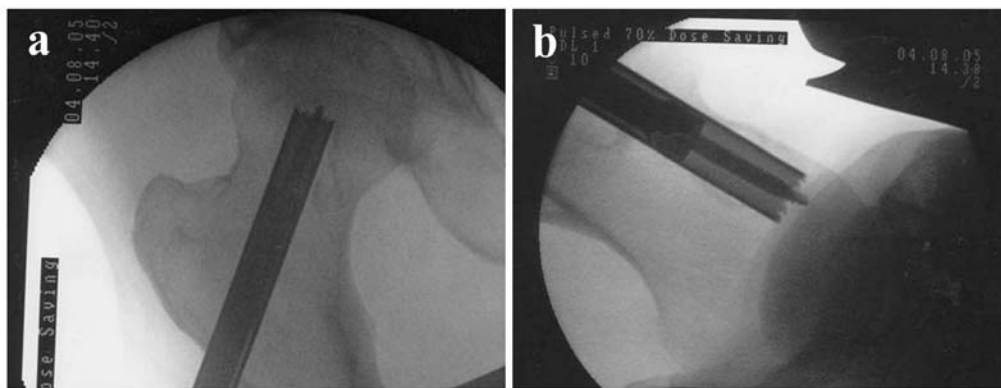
Intra-op radiographs (Case 1). Image intensifier images demonstrating technique using apple corer railroaded over guide wire to enucleate the cyst.
